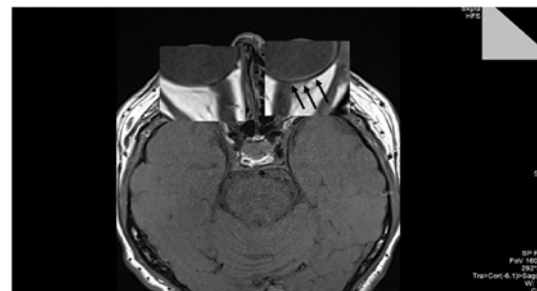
Axial T2 with fat suppression MRI, revealing thickening with enhancement involving outer and inner aspect of left posterior sclera (black arrows).
